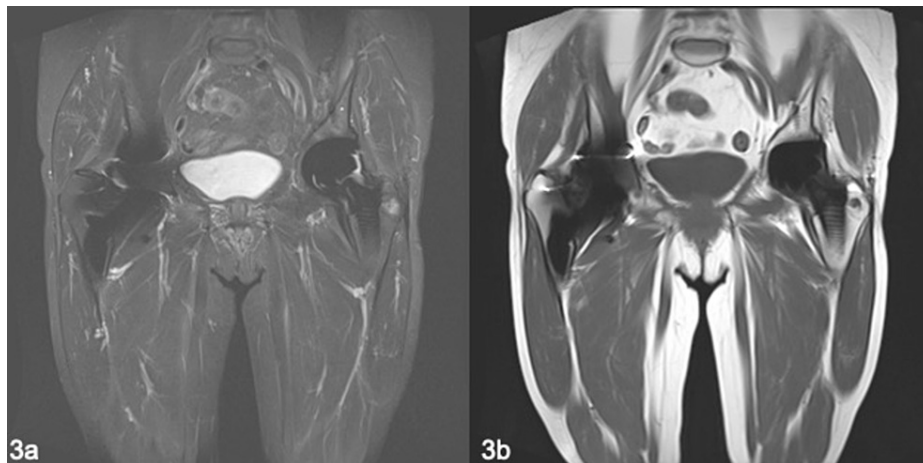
MRI of the pseudotumour in 2020 showing significant regression in size.
